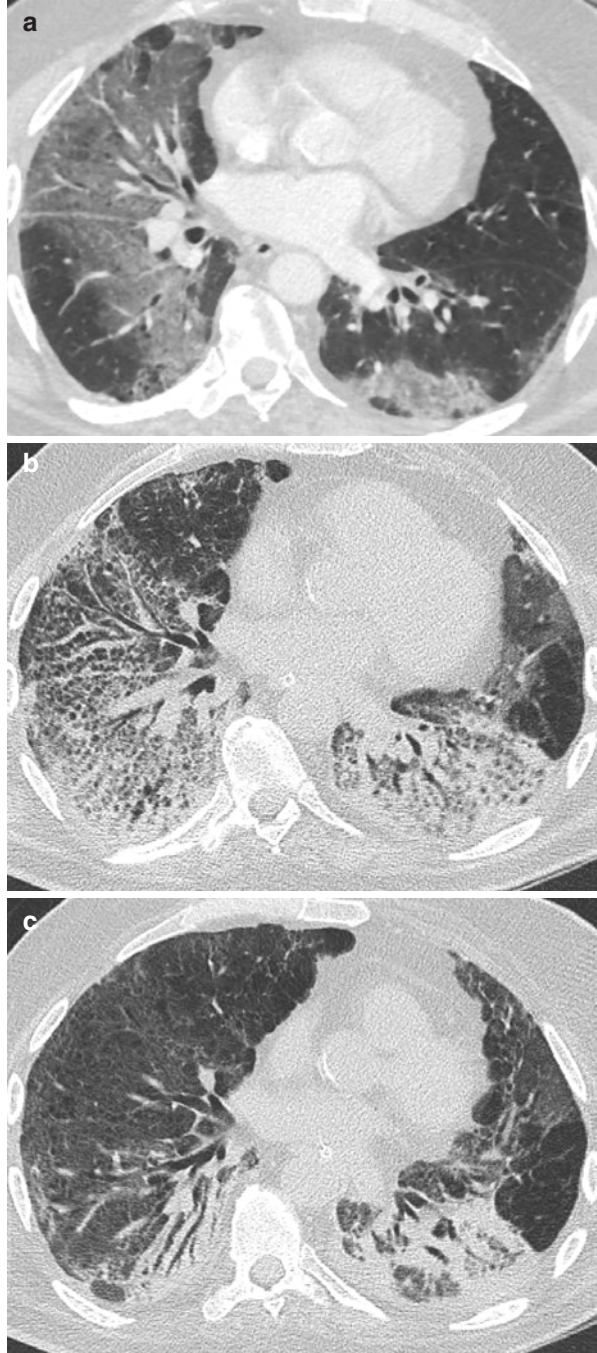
TNF inhibitor pulmonary toxicity in a patient with rheumatoid arthritis and pre-existing interstitial lung disease. (a) Before treatment there are subpleural reticular abnormalities with traction bronchiectasis consistent with fibrotic lung disease. (b) Following treatment with TNF inhibitor, progressive dyspnoea prompted further HRCT evaluation which demonstrated new homogeneous ground-glass opacities throughout both lungs consistent with diffuse alveolar damage. An important differential diagnosis not to overlook in this setting is opportunistic infection (see text)
